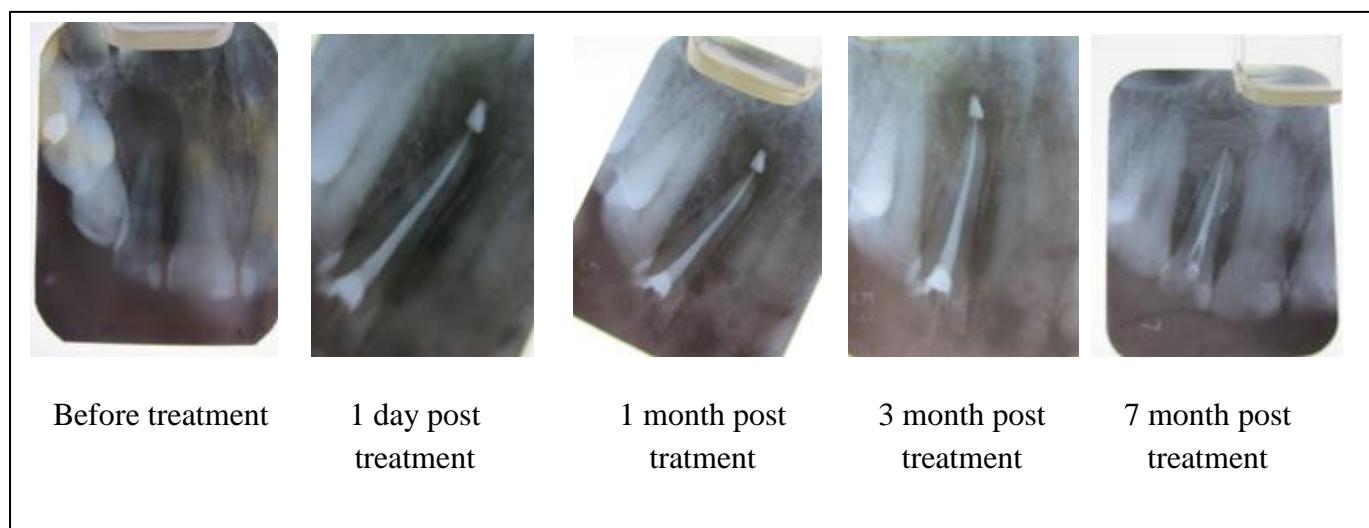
Radiographic picture
